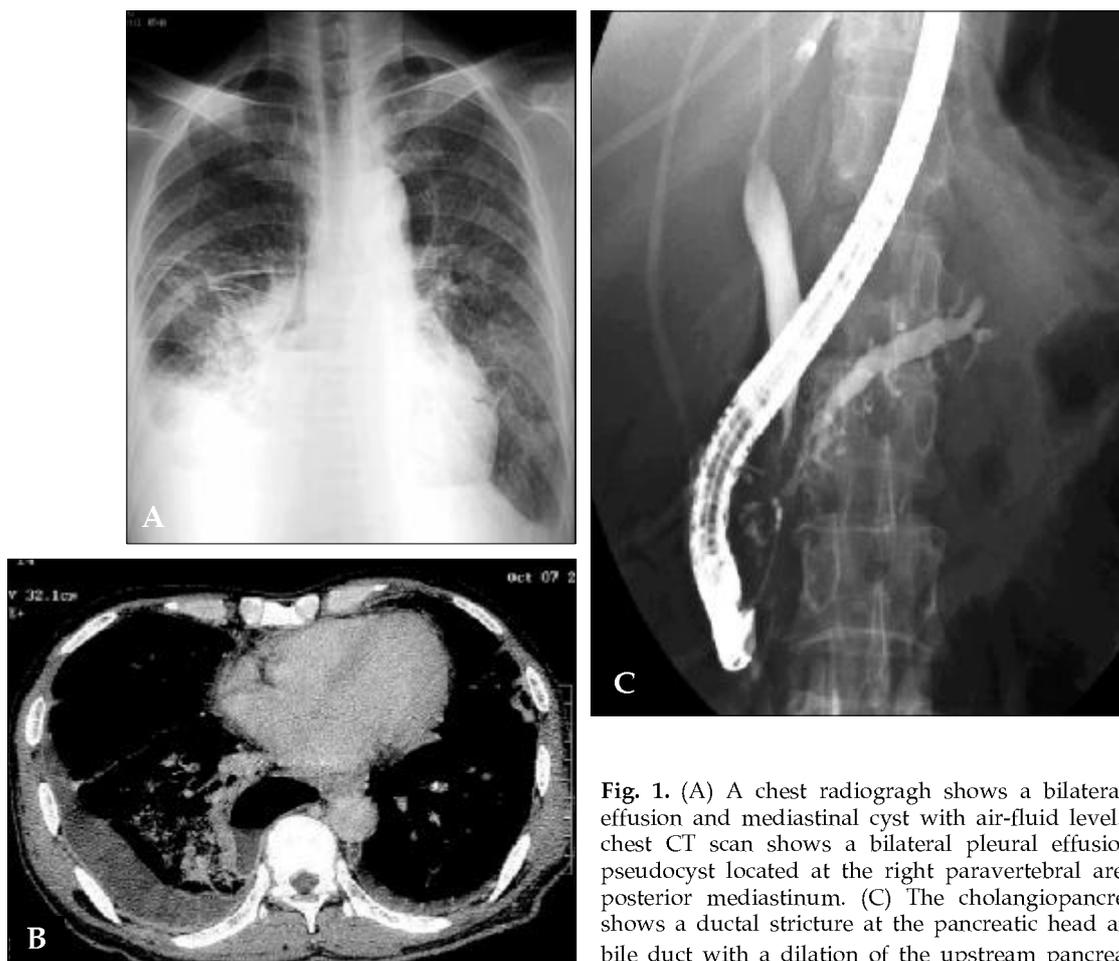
(A) A chest radiograph shows a bilateral pleural effusion and mediastinal cyst with air-fluid level. (B) The chest CT scan shows a bilateral pleural effusion and a pseudocyst located at the right paravertebral area in the posterior mediastinum. (C) The cholangiopancreatogram shows a ductal stricture at the pancreatic head and distal bile duct with a dilation of the upstream pancreatic duct.
